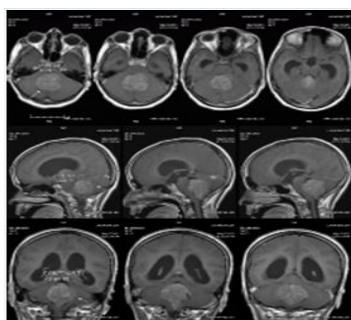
CT picture showing tumor in cerebellar region with hydrocephalus.
